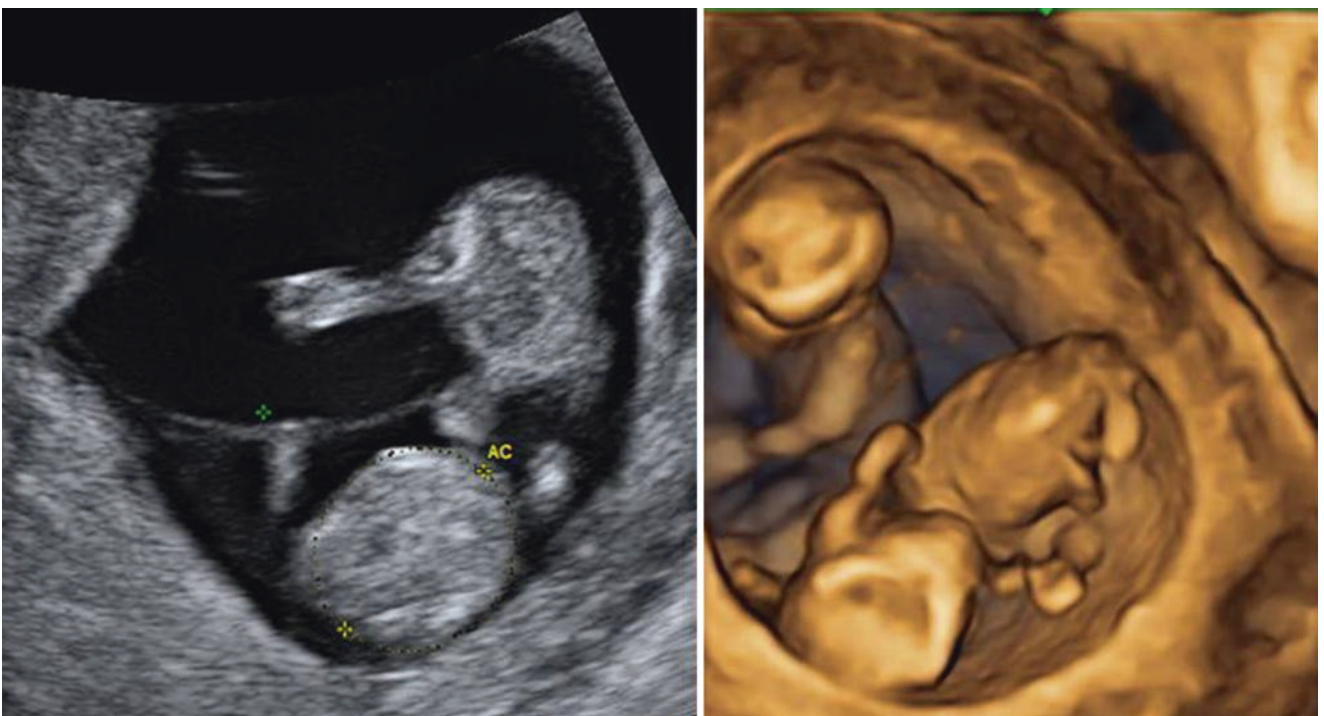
Ultrasonographic picture of monozygotic twins at 12 weeks. On the *left*, 2D picture with visible thin intertwin membrane and no bulging of placental tissue into the base of the membrane (T sign). On the *right*, same monozygotic twins in 3D
